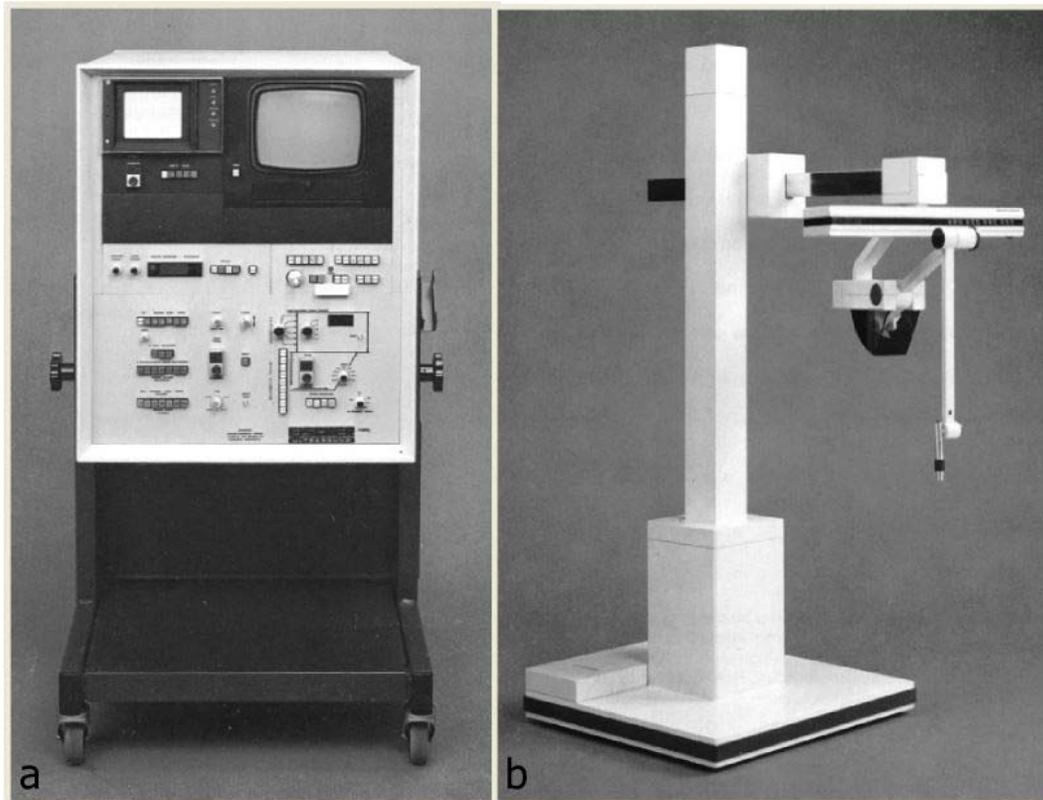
a) Fischer 4200S console. From Fischer Ultrasound sales leaflet for 4200S [74]. b) Articulated arm option for the Fischer 4200S. From Fischer Ultrasound sales leaflet for the Articulated Scan Arm [76].
